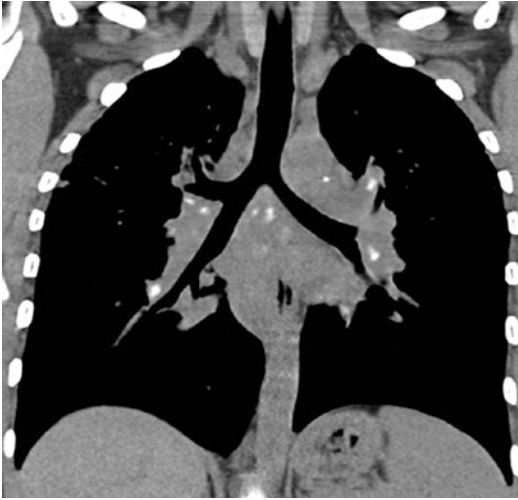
27-year-old woman with chronic sarcoidosis. Coronal CT image displays extensive mediastinal lymphadenopathy. Lymph nodes show punctate calcifications.
